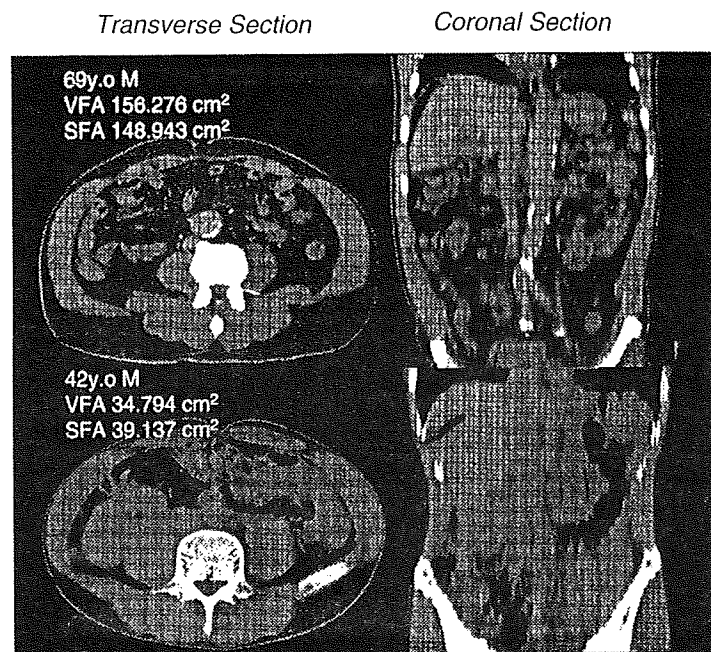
Representative MDCT images used for determination of visceral fat area and subcutaneous fat area. CT slices at the level of the umbilicus were used for the determination of areas. VFA, visceral fat area; SFA, subcutaneous fat area. Upper: a case of visceral obesity; Lower: a non-obese case.
